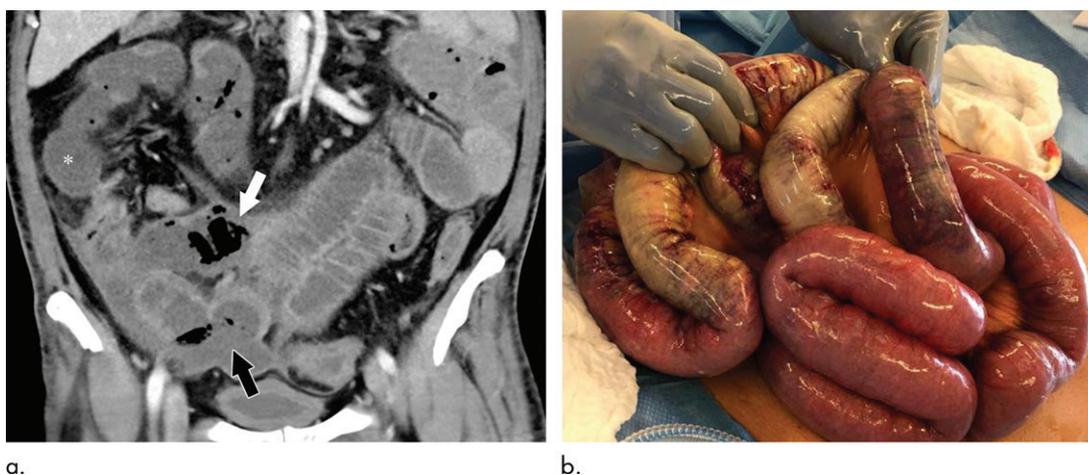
(a) Coronal CT image of the abdomen and pelvis with intravenous contrast material in a 47-year-old man with abdominal tenderness shows typical findings of mesenteric ischemia and infarction, including pneumatosis intestinalis (white arrow) and nonenhancing bowel (*). Frank discontinuity of a thickened loop of small bowel in the pelvis (black arrow) is in keeping with perforation. (b) These findings are confirmed at laparotomy, with the additional observation of an atypical yellow discoloration of the bowel.
